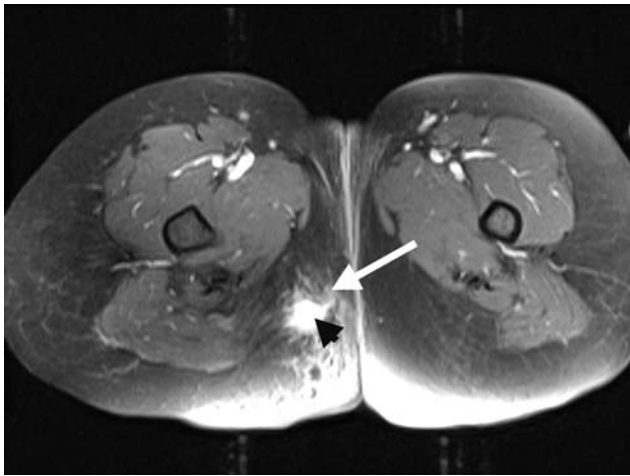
Axial fat-saturated T1-weighted MR image shows an oval enhanced structure (*arrow*) after iv. administration of contrast medium. It contains nonenhancing pus (*black arrowhead*) due to an abscess in the right perianal fossa. The inflammatory changes in the surrounding tissue are well visible in the right perianal fossa.
